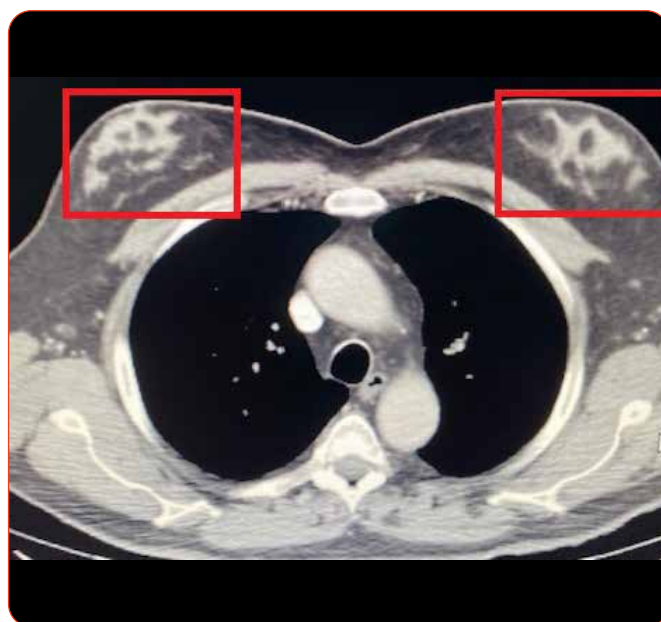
Axial CT scan showing enlarged breasts (red rectangles).
